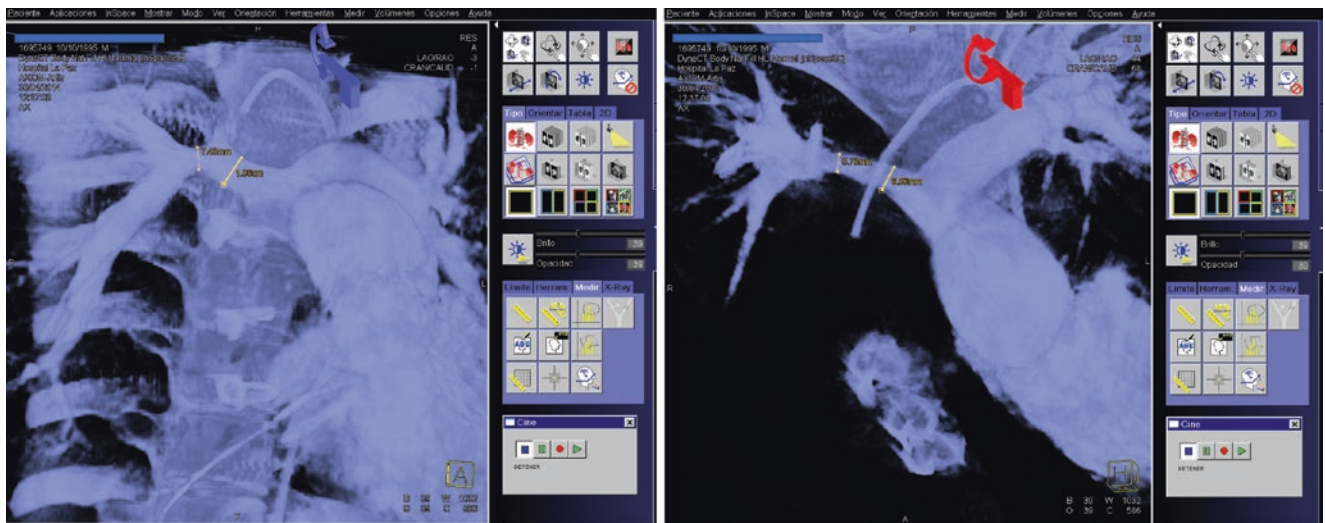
Camera angles. Angiographic computed tomography helps to choose best angles to take measures, but these angles are not always achievable with actual equipment, and alternative angles are necessary.
